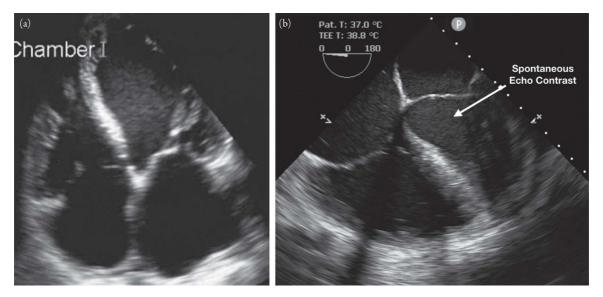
Spontaneous echo contrast in the left ventricle on an apical 4-chamber window (a) and on transesophageal echocardiography (b).
